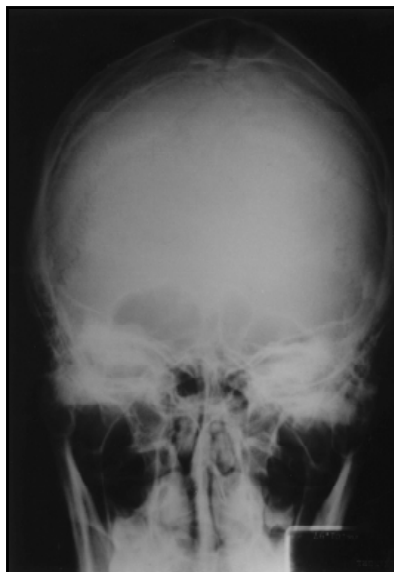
Patient's skull roentgenogram shows a lytic biparietal lesion.
